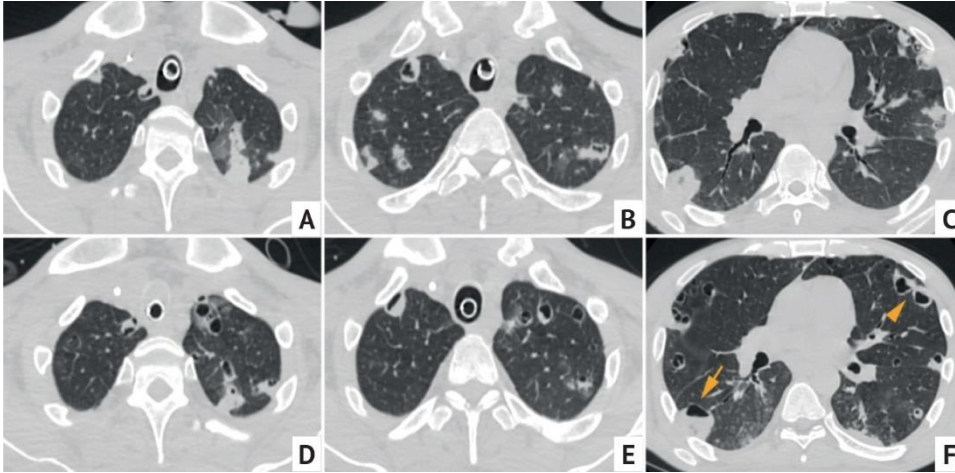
Axial chest CT images of a 35 y.o patient from 19.08.2018 (A–C) and from 24.08.2018 (D–F) at the corresponding levels. SPE as a complication of IE of the TV. New lungs nodules in follow-up images are noted, as well as the formation of cavities against the background of opacities (arrows)
